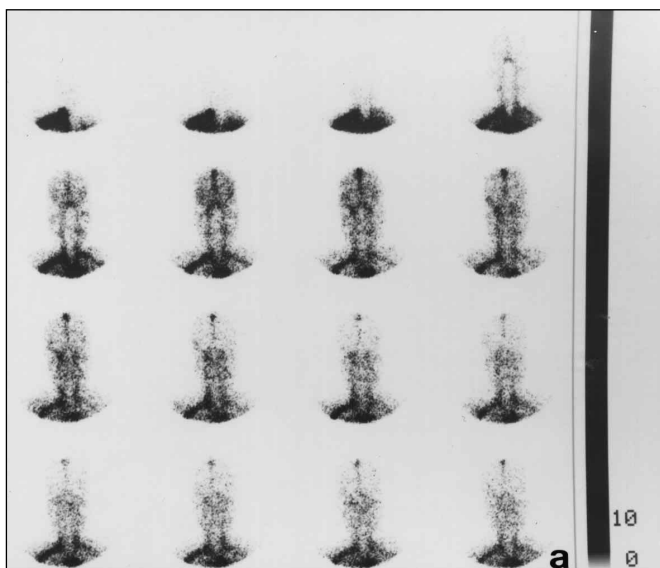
Tc-99m labeled RBC scintigraphy demonstrating a typical "perfusion blood-pool mismatch" of cavernous hemangioma in the right orbit.
